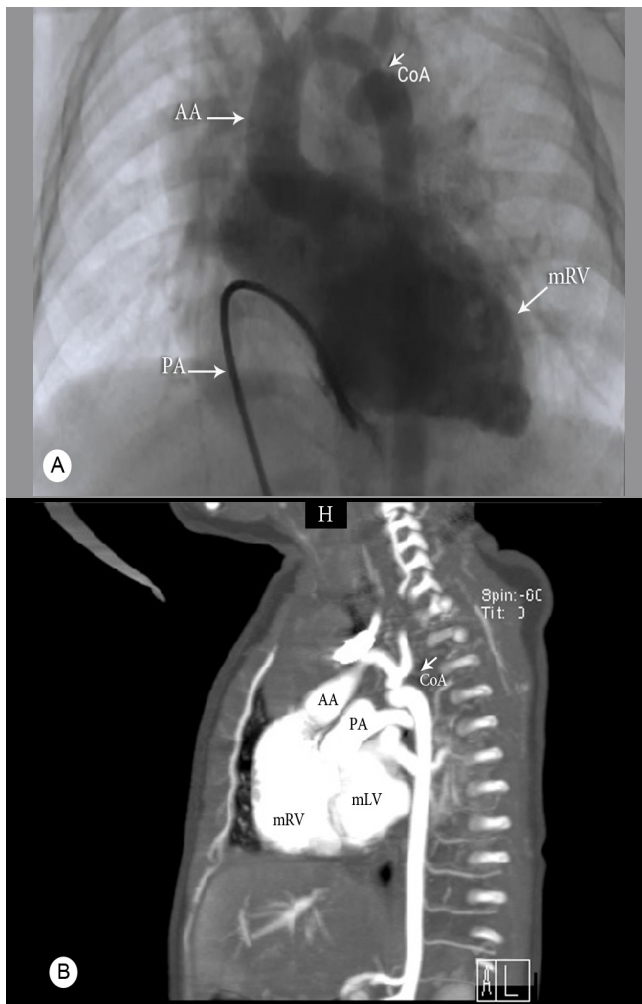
A) This image depicts the course of a venous catheter in our patient diagnosed with congenitally corrected transposition of the great arteries as captured in the anteroposterior view. The catheter, inserted via the right femoral vein, was navigated through the venous system into the right atrium, crossing the tricuspid valve into the morphologic left ventricle (mLV). After the injection in the recirculation phase, with the return of the patient's blood to the left atrium and the morphologic right ventricle (mRV) as the systemic ventricle, the blood entered the ascending aorta (AA) and the arch. Subsequently, the coarctation area was visualized. The contrast medium was injected at a speed of 7 mL/s for a total volume of 10 mL. B) Coarctation of the aorta (CoA) was confirmed in the computed tomography angiogram.
